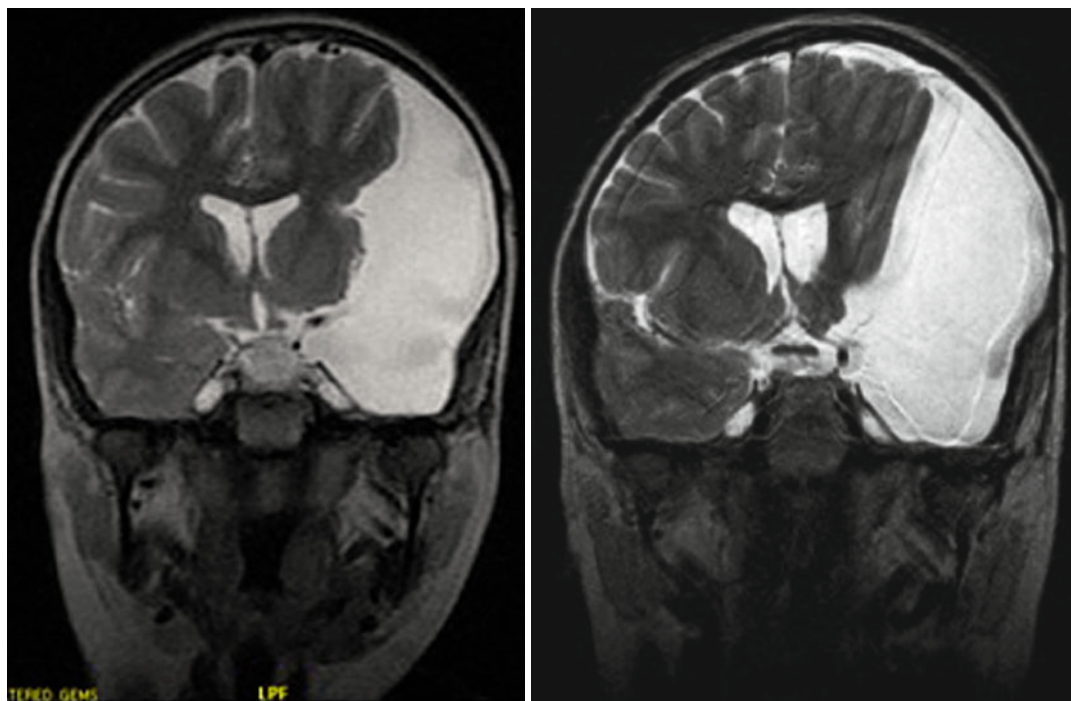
Preoperative (*left*) and postoperative (*right*) coronal T2w MRI images of left Sylvian arachnoid cyst. Marsupialization of the cyst linings resulted in minimal
